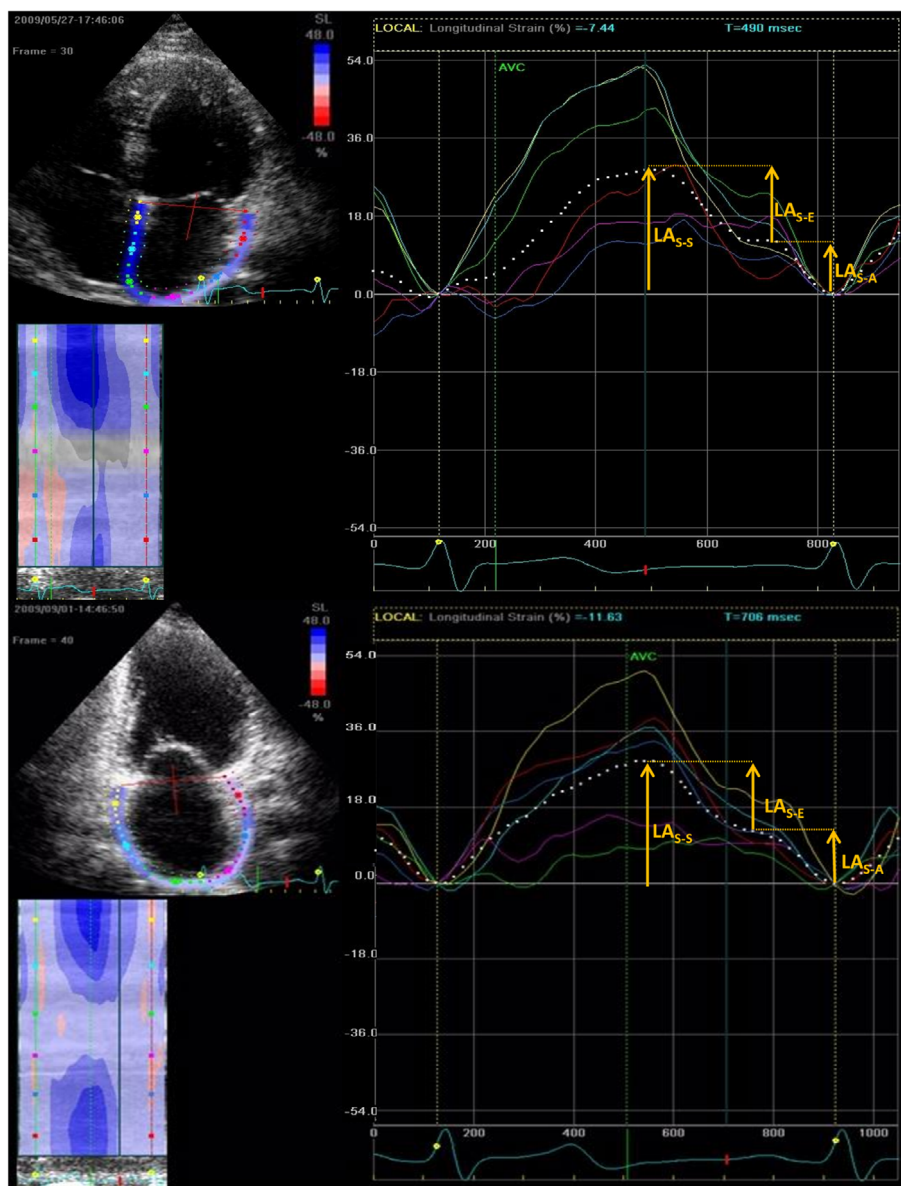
Two-dimensional strain curves acquired from the apical four- and two-chamber views. It shows the strain curves of the left atrium and the measurement method of the parameters in a patient with hypertensive retinopathy
